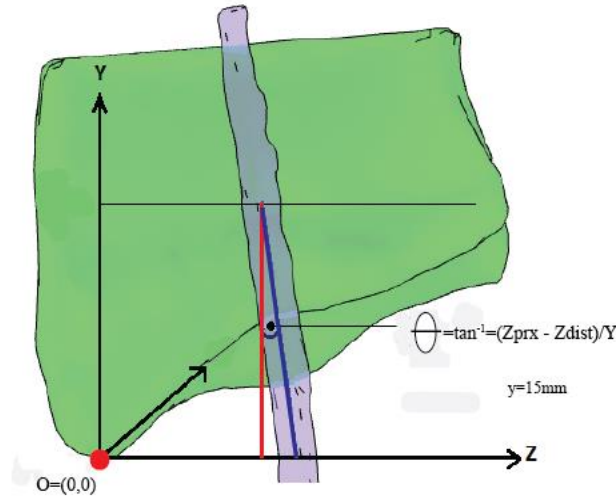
Anterior view of the radius and a sample tendon, depicting the calculation of frontal tendon angles with respect to the forearm's long axis, proximal to the CT. Positive angles open ulnarly at the proximal end.
